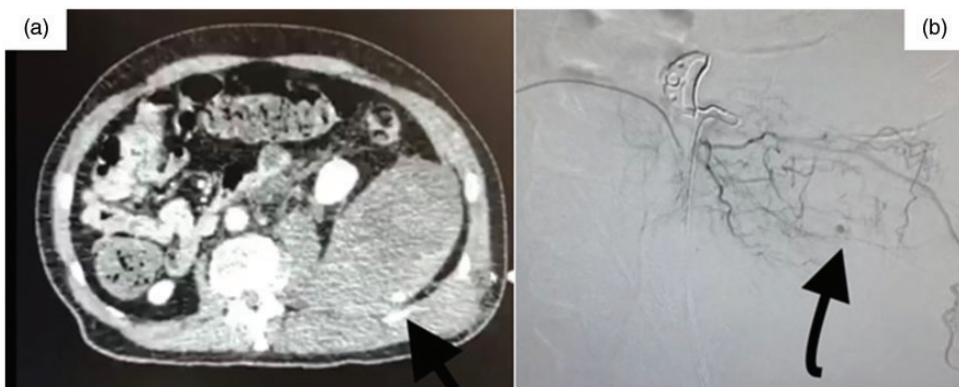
Imaging results from Patient 2: (a) Site of contrast extravasation in the computed tomography (CT) scan and (b) Site of contrast extravasation (black arrow) seen during angioembolization.
